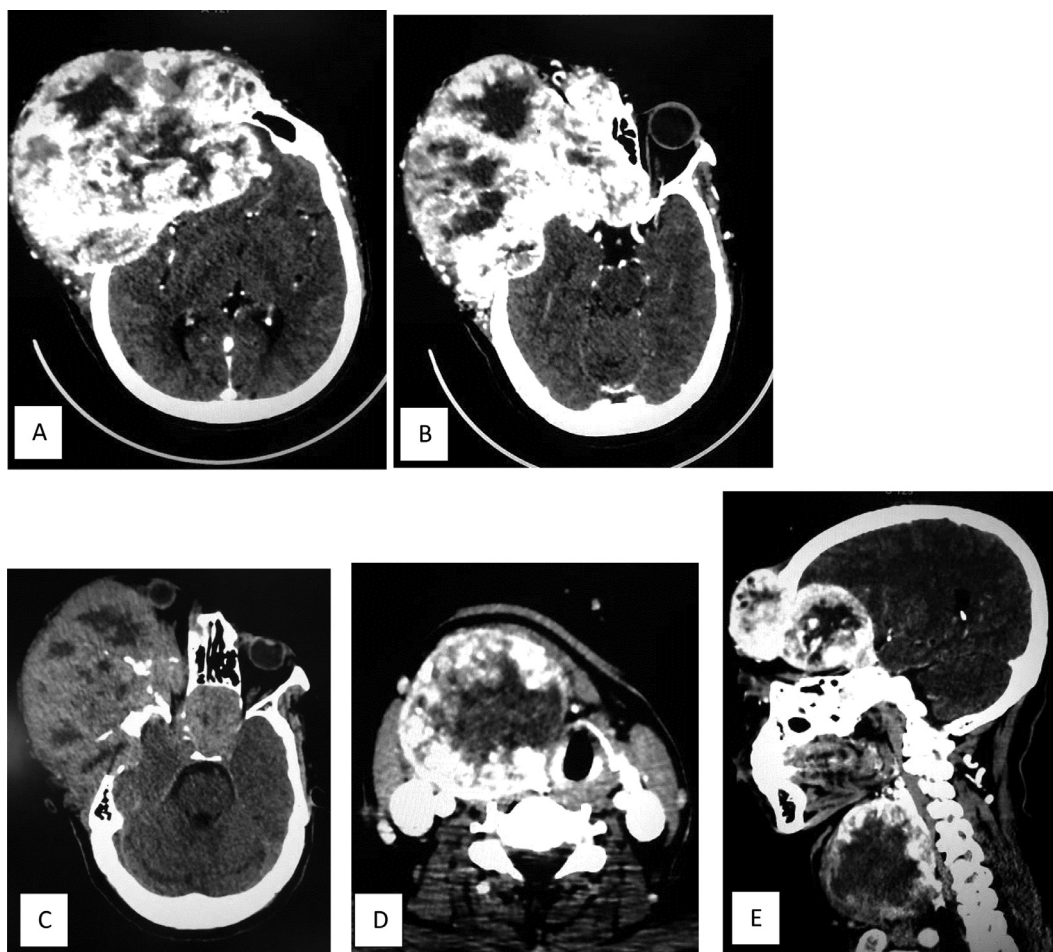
Axial sections with contrast injection (A, B) showing the highly vascularized craniofacial tumor, with endocranial involvement (facial sinuses, extradural space). Axial section without contrast medium injection (C) showing a right orbital extension of the tumor with exophthalmos. Axial and sagittal sections (D and E) showing the thyroid tumor with similar CT characteristics to the craniofacial mass
